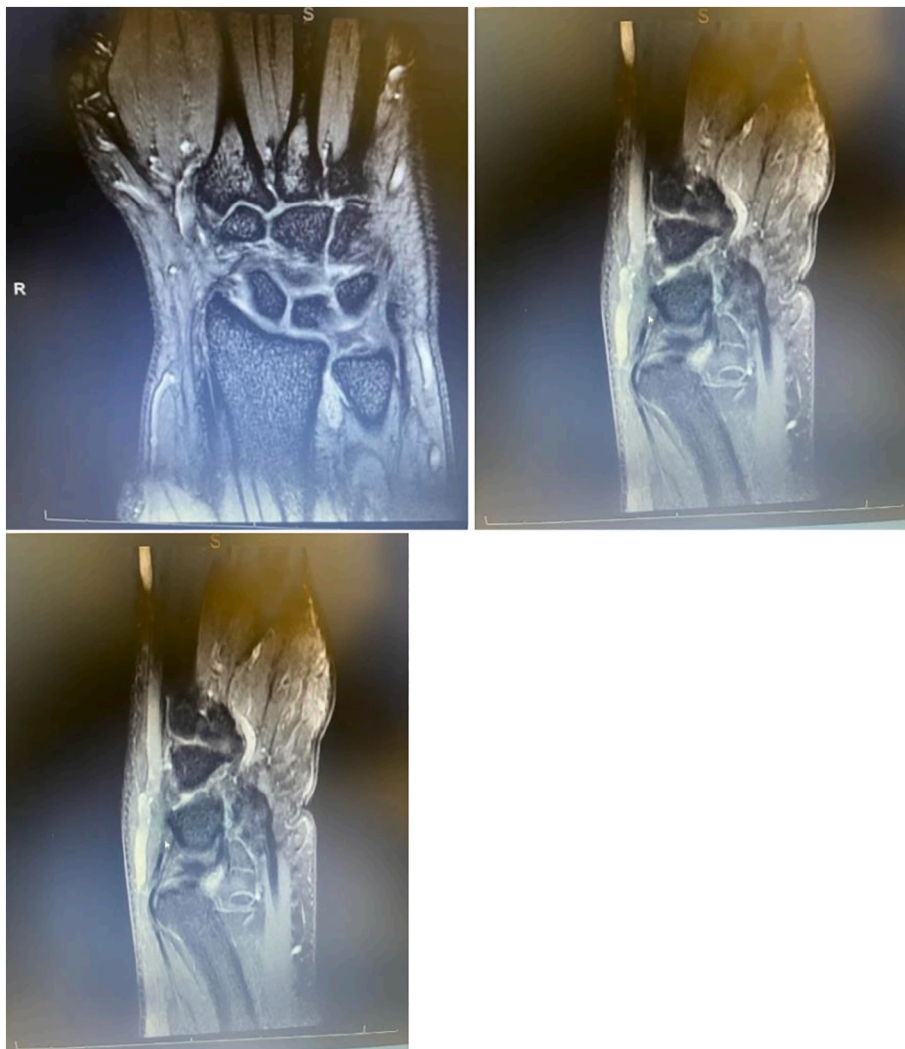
Magnetic resonance imaging was ordered which shows large DRUJ effusion associated with synovitis with multiple low- intensity foci corresponding to subtle calcifications which are all consistent with synovial chondromatosis.
